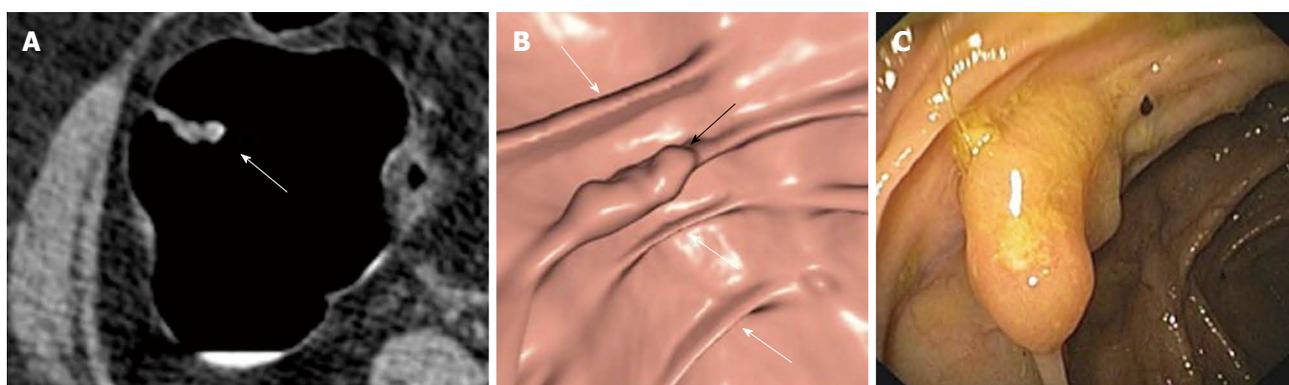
Non-polypoid (flat) lesion: advanced adenoma. A: On 2D axial computed tomography image an irregularly thickened fold (arrow) is detected; B: On 3D endoluminal image the lesion is better appreciated (black arrow), in particular if compared with the normal adjacent colonic folds (white arrows); C: The same lesion at colonoscopy before removal.
